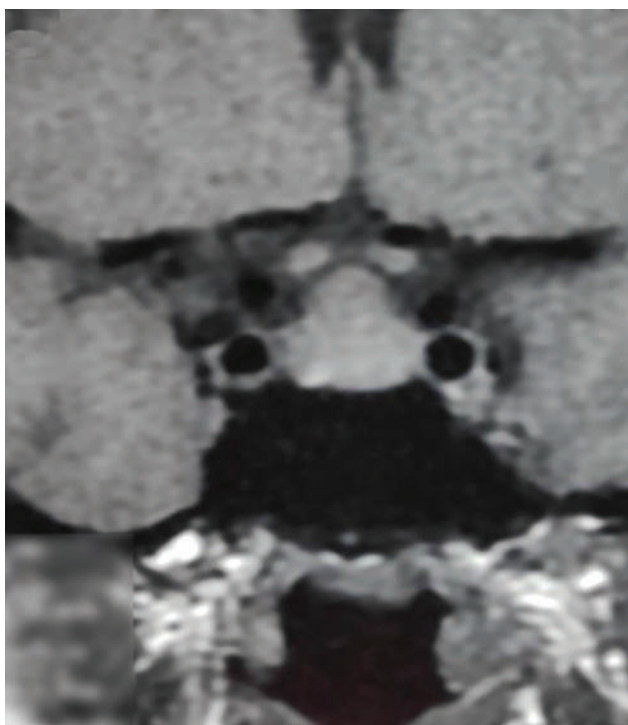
Preoperative coronal T1-weighted image depicting similar pituitary enlargement as in Figures 1 and 2.
